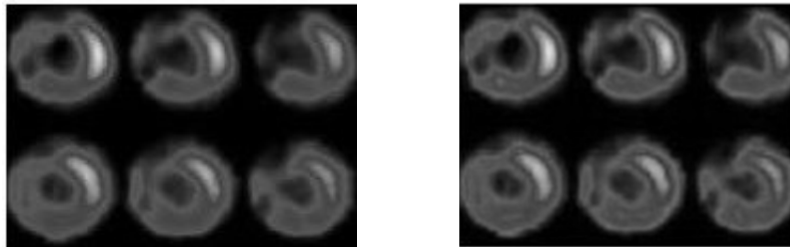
Cardiac SPECT image slices (high tracer content region) and the corresponding enhanced slices using the proposed method
